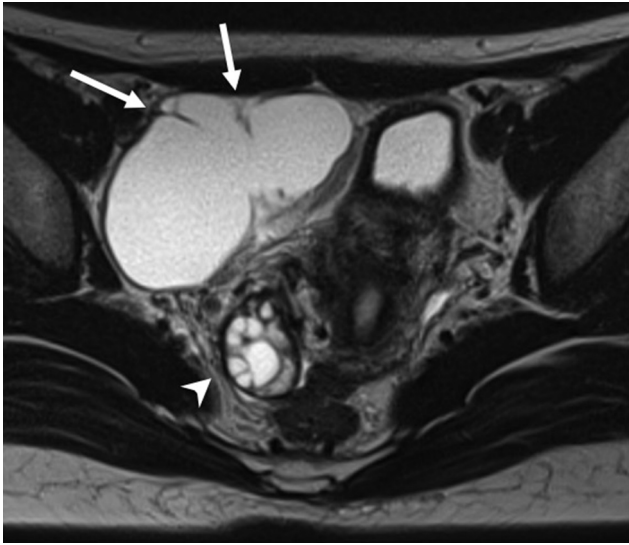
Axial T2-weighted magnetic resonance image showing a cystic lesion in the right pelvis with incomplete wall-like structures (arrows). An intact right ovary can be observed (arrowhead).
